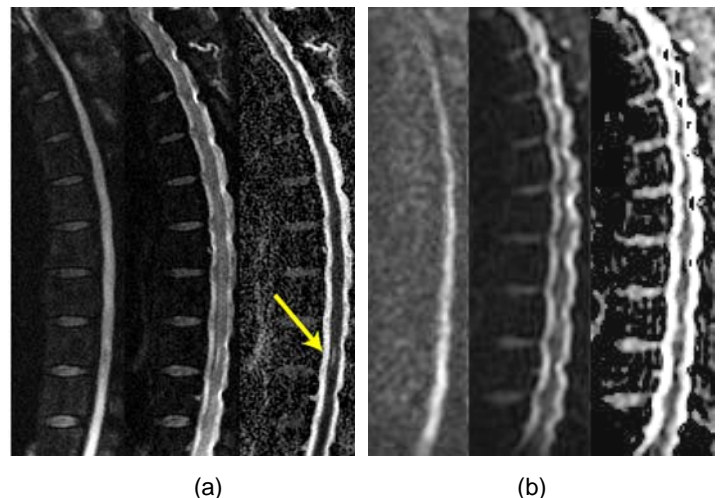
Midline sagittal (a) rFOV and (b) full-FOV DWI of the thoracic spinal cord in a 49 year old man imaged to evaluate for possible nerve sheath tumors. From left to right are isotropic DWI (b=500 s/mm²), T2-weighted, and ADC maps. Note the higher resolution and reduced distortion on the rFOV study, as well as the improved visualization of the vertebral bodies. The higher resolution allowed visualization of a tiny structure in the lower thoracic cord, likely a dilated central canal ("terminal ventricle"); the arrow demonstrates high ADC consistent with fluid.
